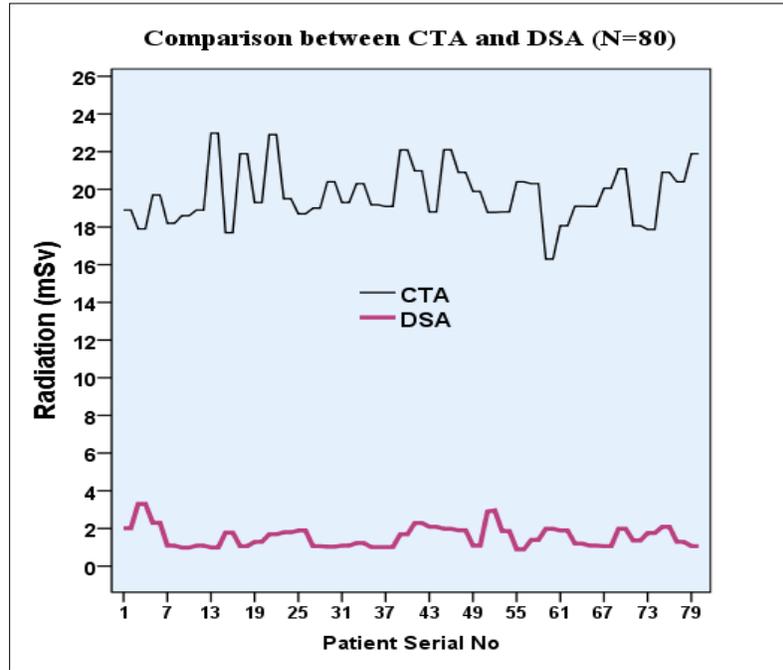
Line graph depicting comparison of radiation doses between CTA and DSA.
